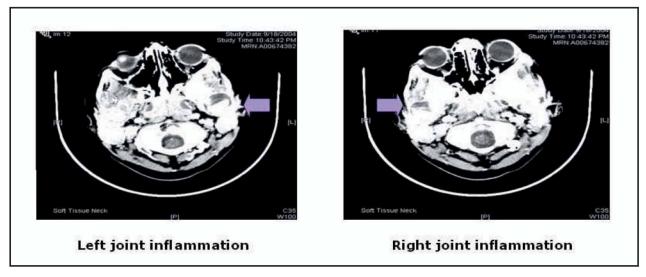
Computed tomography scan of an 8-year-old male subsequent to diagnosis of Lyme disease.
